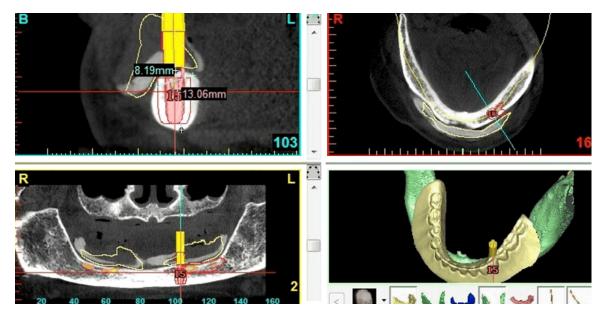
Treatment planning and implant selection using a computer program (Simplant®) and cone beam computed tomography (CBCT) scans.
